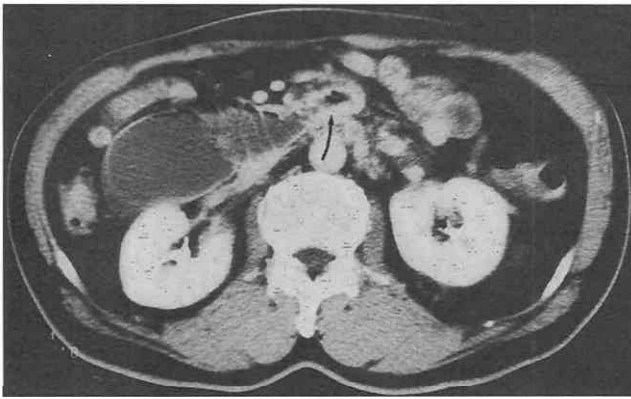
Primary duodenal carcinoma. CT scan shows concentric bowel wall thickening (*arrow*), producing low-grade bowel obstruction. Note lymphadenopathy in the paraortic and periduodenal regions.
